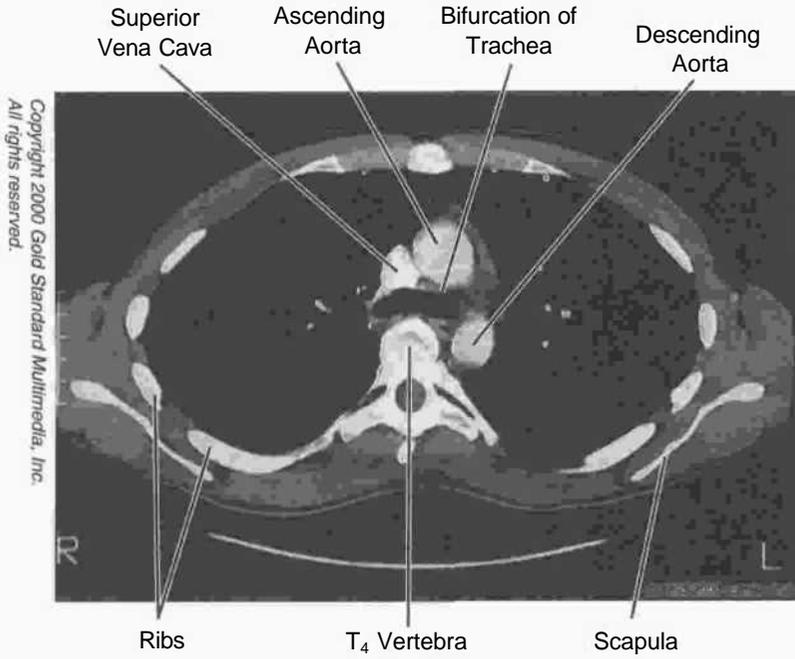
Figure ill-2-23. Chest: CT, T₄
